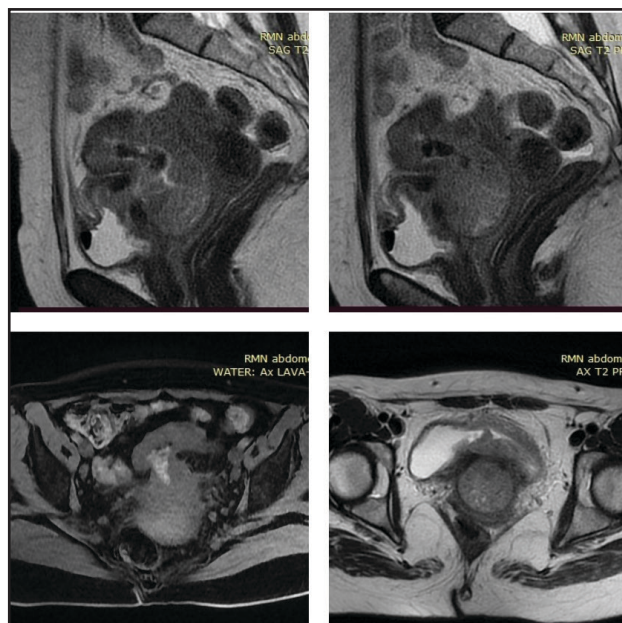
Magnetic resonance images show a large tumor directly invading the uterus and urinary bladder with colovesical fistula
